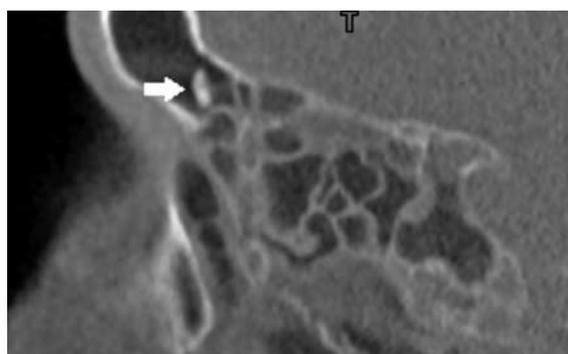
Bony nodule in the frontal sinus (CBCT, sagittal view)
